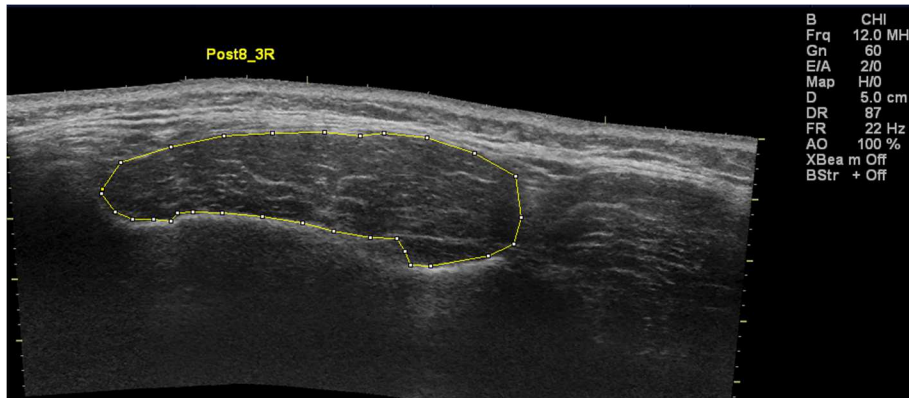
Ultrasound Imaging Analysis
